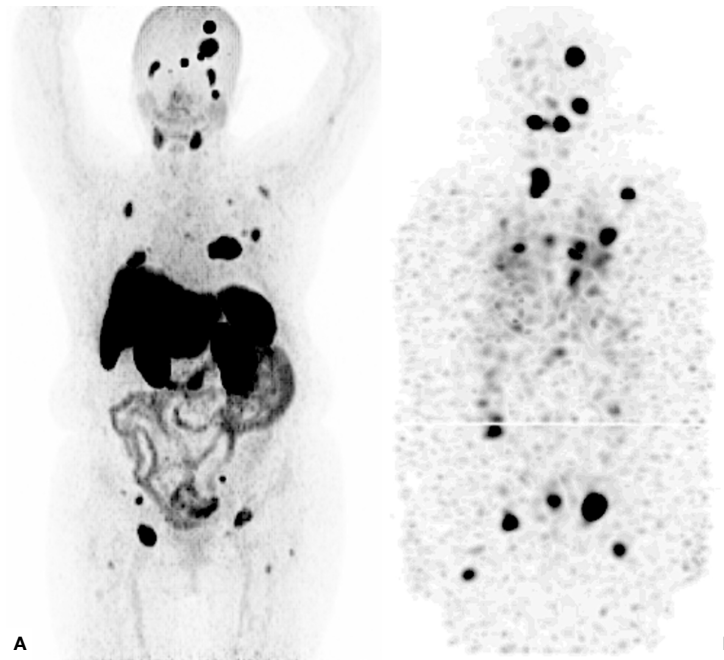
^{131}I – Post Therapy Whole Body Scan. 42 years old male, papillary thyroid carcinoma classic variant. Thyroglobulin 114. RAI cumulative dose (16650 MBq) Maximum Intensity Projections. (A) ^{68}Ga - PSMA PET/CT. (B) ^{131}I - SPECT/CT.
